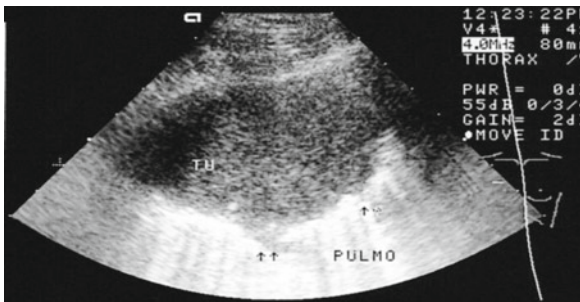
A 40-year-old man with recurrent eosinophilic pleural effusion. X-rays showed a peripheral lesion in the upper lobe of the left lung. On sonography in the anterior axillary line in the second intercostal region, there is a hypoechoic peripheral pulmonary lesion with central vessels and rather sharp margins. Removal of the lesion by thoracoscopy led to the diagnosis of hyalinosis and callus. The source of the pleural effusions is still not clear
